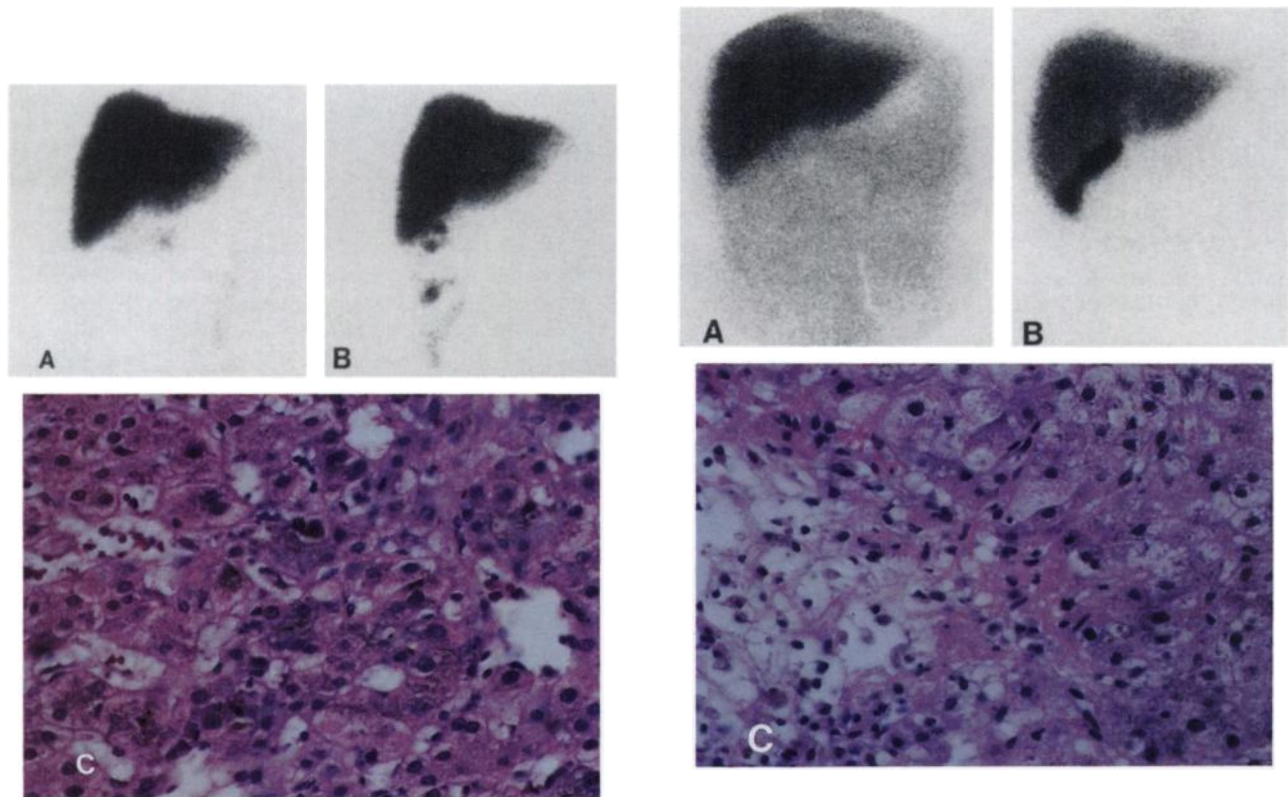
The cardiac blood pool is only barely visible at 1 min (A), indicating normal uptake. The 30-min image (B) shows intestinal radioactivity but no decrease in parenchymal intensity from 10 min, indicating severely abnormal excretion. Biopsy (C) shows normal hepatocytes (HD score = 0). Bile collections are seen in hepatocytes, canaliculi, and ductules (CS score = 2). These biopsy findings of normal hepatocytes and cholestasis correspond to the scintigraphic findings of normal uptake and impaired excretion.
